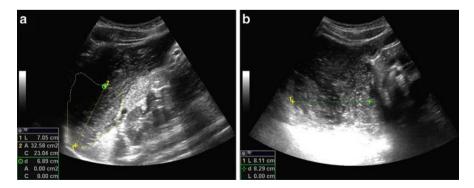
2D ultrasound images of the proximal stomach in (a) sagittal section and (b) oblique frontal section
